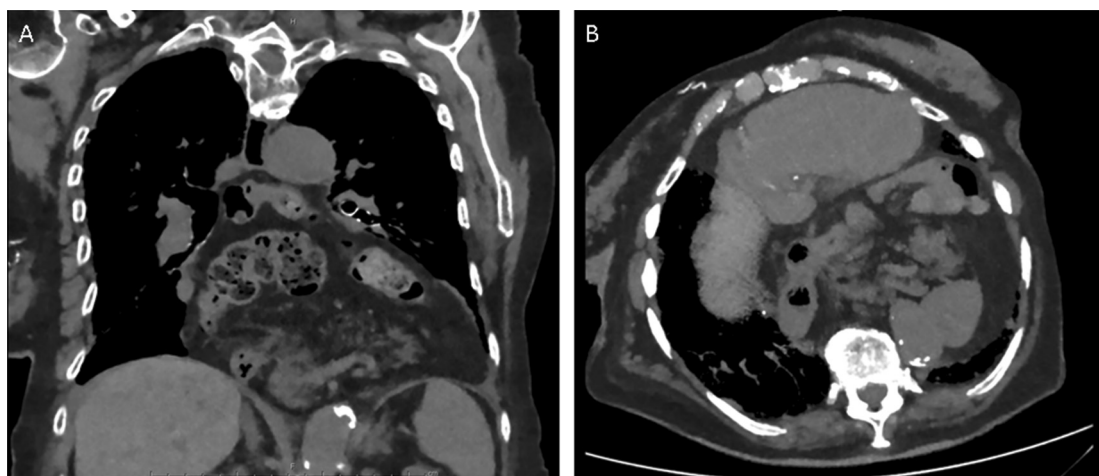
Computed tomography. (A) Thorax coronal view; and (B) axial view demonstrating a large hiatal hernia containing the entire stomach, proximal duodenum, a portion of the transverse and descending colon, and the pancreas.
